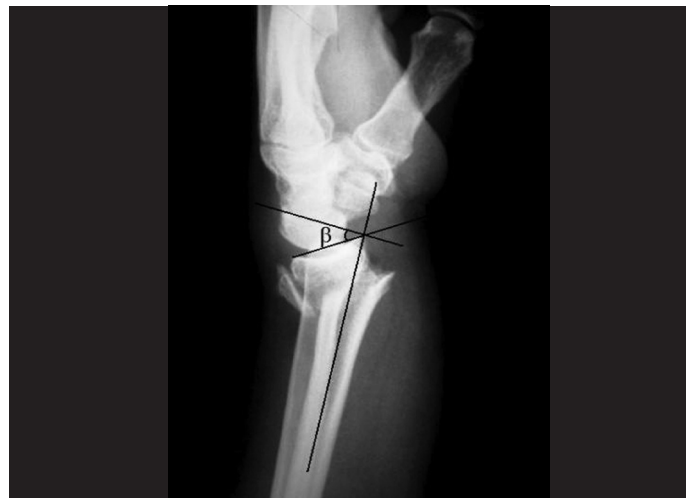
Preoperative radiograph on wrist in lateral view, showing a fracture of the distal radius with metaphyseal dorsal comminution and dorsal deviation. The volar tilt (β) is demonstrated on the radiograph.
